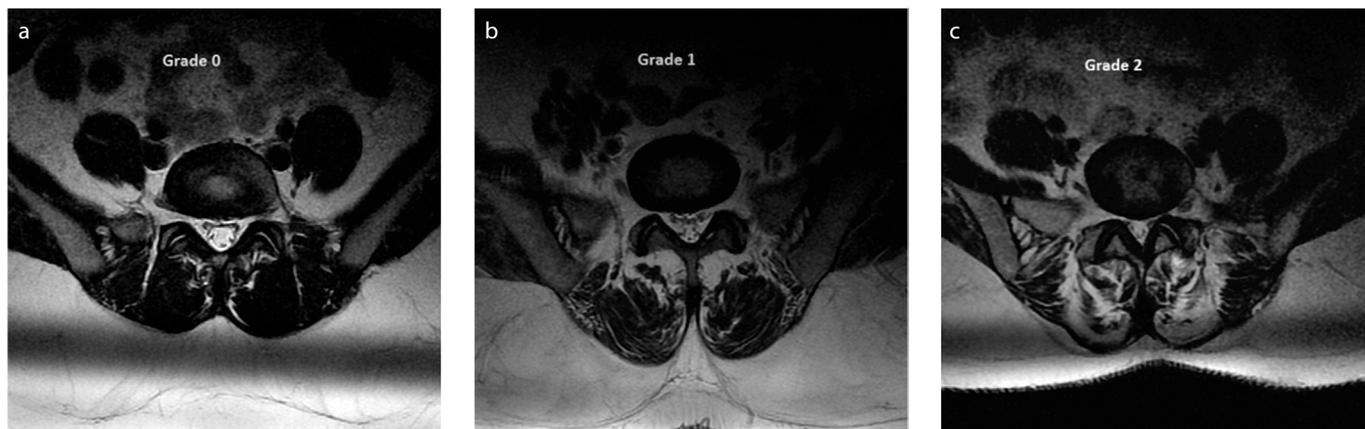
a–c. Examples of lumbar multifidus muscle (LMM) atrophy as seen on axial T2-weighted images. Panel (a) shows normal condition (grade 0); panel (b) shows grade 1 atrophy with slight fat infiltration (10%–50%); panel (c) shows grade 2 atrophy with severe fat infiltration (>50%).
